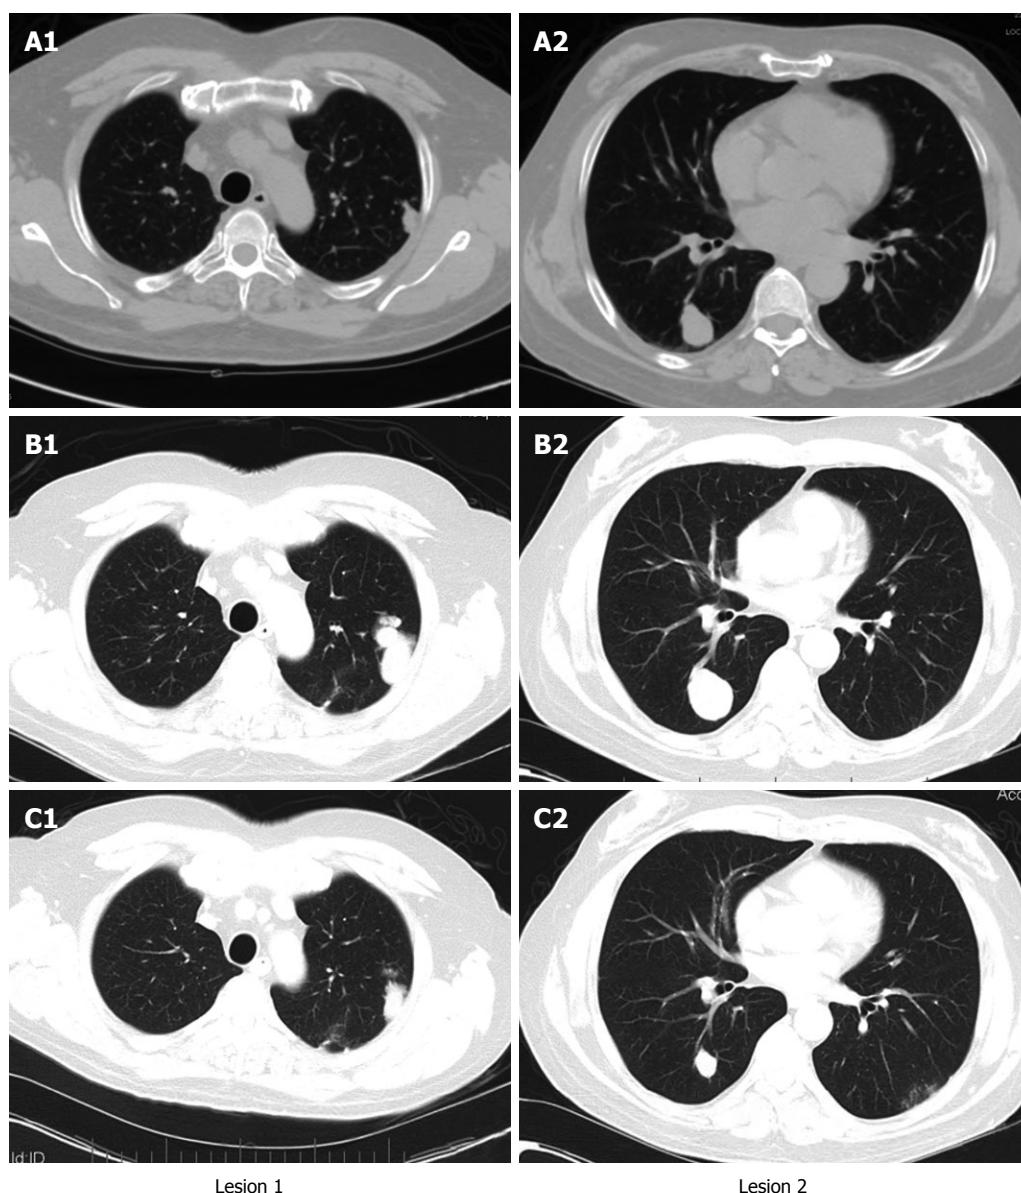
Computed tomographs of chest at different time points of the treatment. The lung lesions were increased in size after sorafenib therapy but significantly reduced in size after sirolimus was introduced in combination with sorafenib. The dates were August 6, 2008 (A), January 26, 2009 (B) and August 26, 2009 (C).
